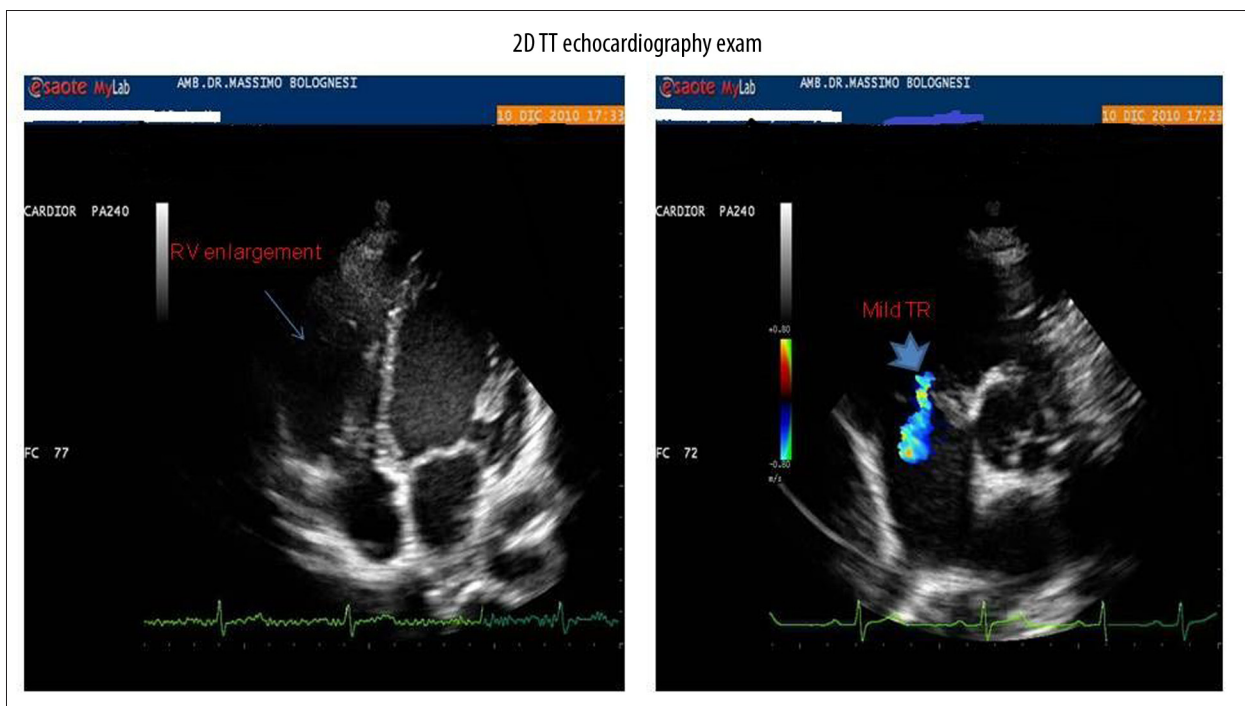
2D Trans-thoracic echocardiography show mild right ventricular enlargement and mild tricuspid regurgitation.
